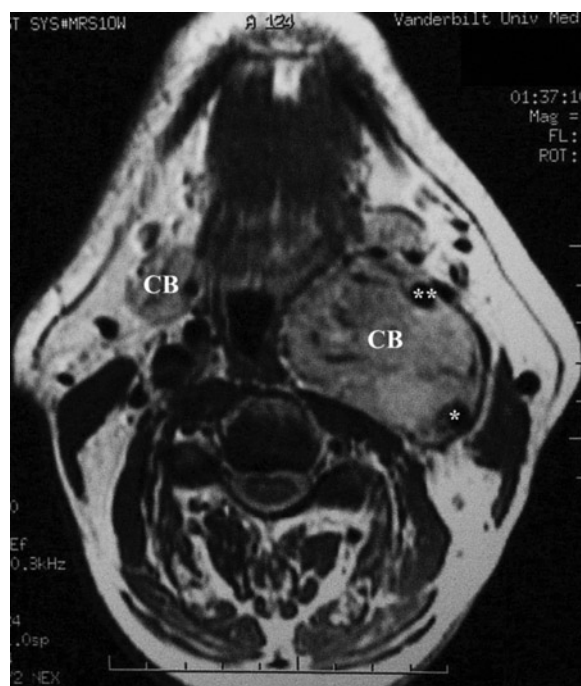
MRI of bilateral carotid body tumors. Note heterogenous appearance due to signal voids and vascularity. *CB* carotid body tumors, *asterisk* internal carotid artery, *double asterisk* external carotid artery
